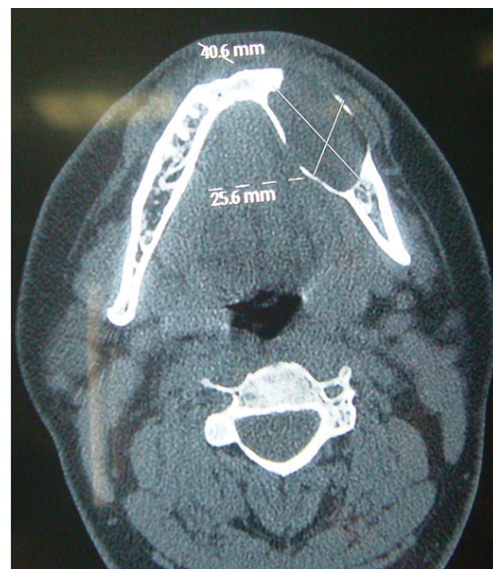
CT scan (axial section) showing buccal and lingual expansion of the mandible
